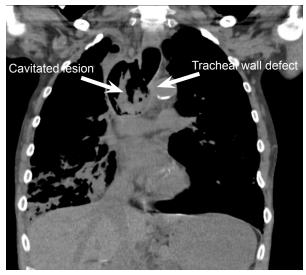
Coronal computed tomography exhibiting a deficit in the right tracheal wall with a cavitary space previously occupied by the large soft tissue mass seen in Figure 2.
